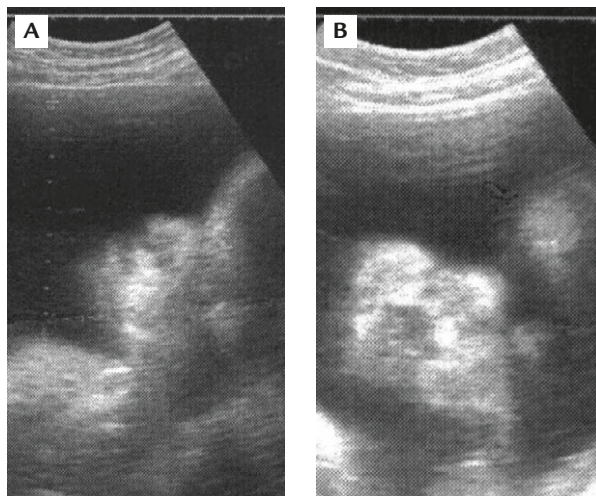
(A) Lateral and (B) anterior views on prenatal ultrasound showing a depressed nasal bridge and midface hypoplasia.
